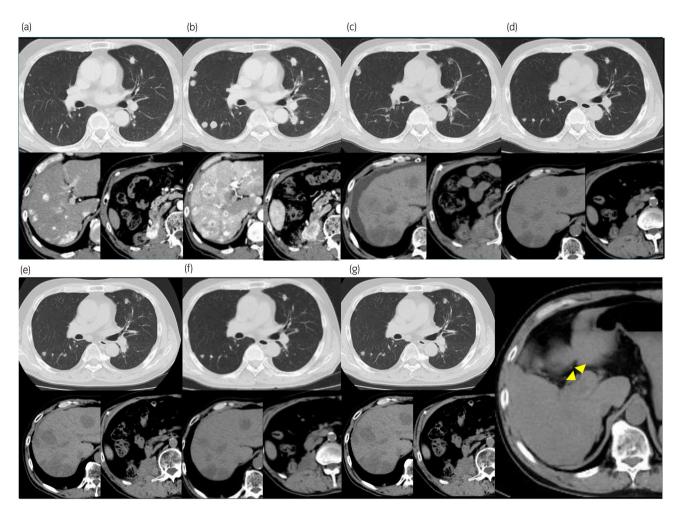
CT images of the treatment course after radical nephrectomy. (a) Two months after radical nephrectomy. Local recurrence, lung, and liver metastases occurred. (b) Two months after the start of IFN-α. Local recurrence and lung and liver metastases enlarged. (c) Four months after the start of Axitinib. Lung metastases shrunk, but local recurrence and liver metastases enlarged. (d) Three months after the start of temsirolimus. Local recurrence and liver metastasis shrunk and ascites disappeared. (e) Twelve months after the start of temsirolimus. Liver metastases enlarged. (f) Eleven months after the start of nivolumab rechallenge. Local recurrence and liver metastases shrunk. (g) Twenty-one months after the start of the nivolumab rechallenge. Liver metastases grew and portal vein invasion (yellow arrowheads) was observed.
